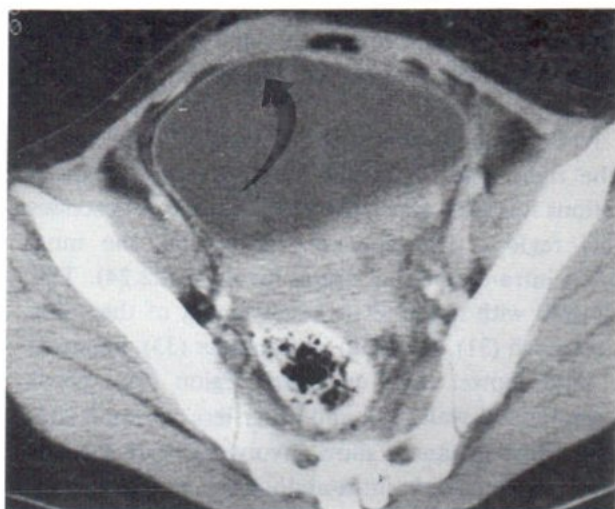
Case II Right anterior abdominal wall lesion, at CT scan
